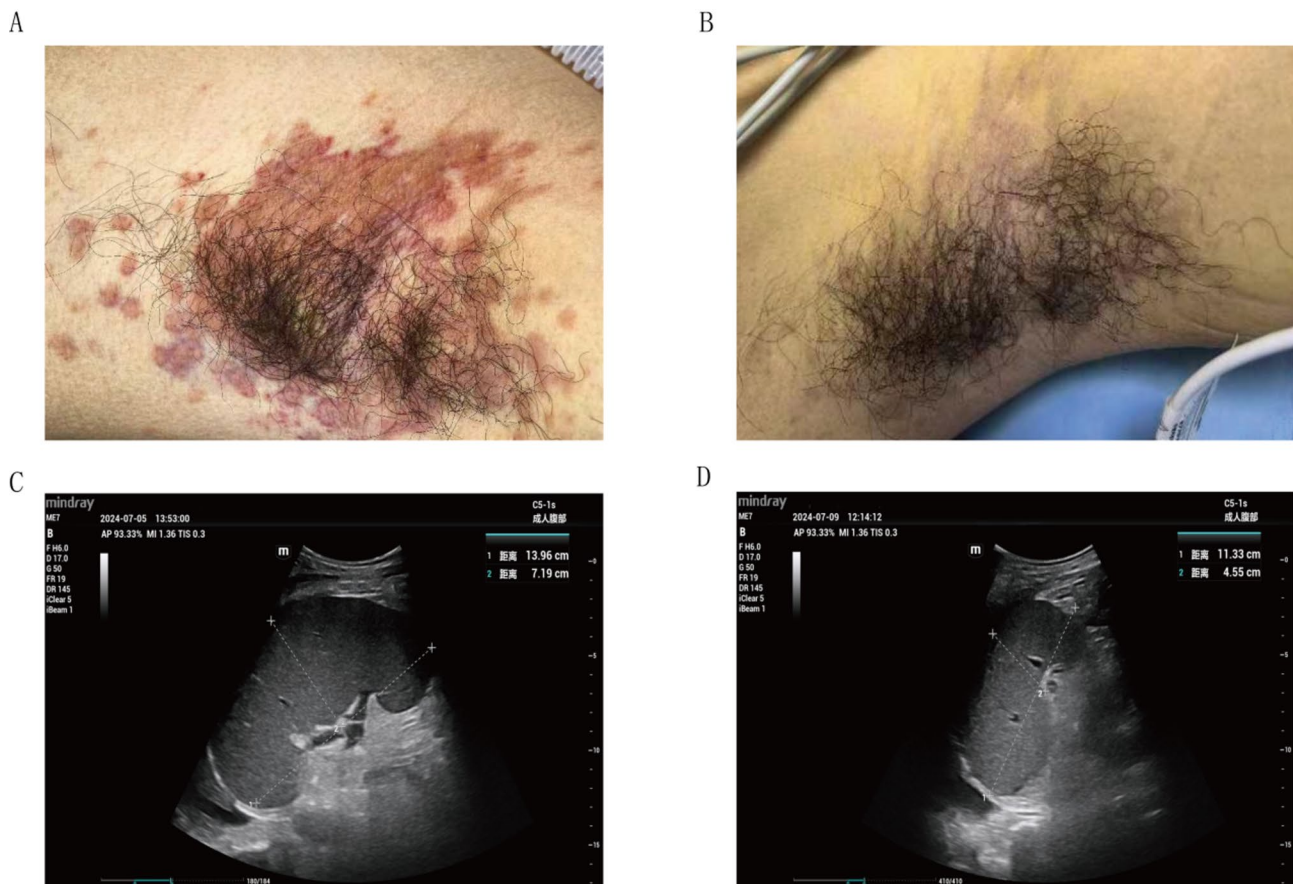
Skin manifestations and imaging findings. A and B. Skin Involvement Before and After Treatment C and D. Ultrasound Findings of the Spleen Before (longitudinal length 13.96 cm, thickness 7.19 cm) and After (longitudinal length 11.33 cm, thickness 4.55 cm) Treatment
